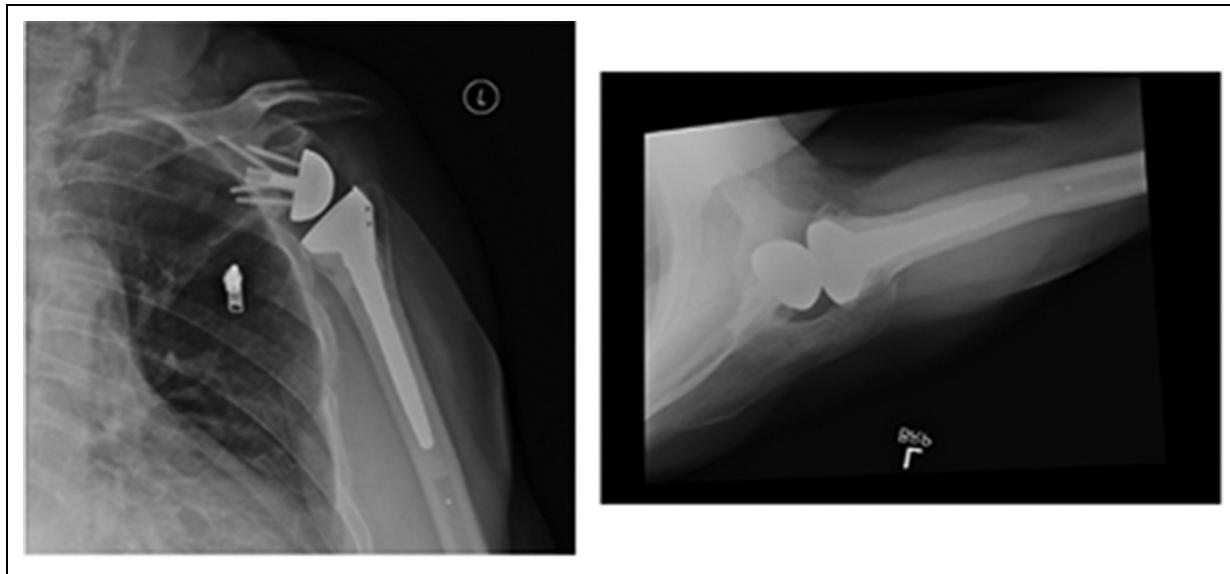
Xray demonstrating Grade A cement mantle with no progression of cement into the diaphyseal canal and stability of the device.
